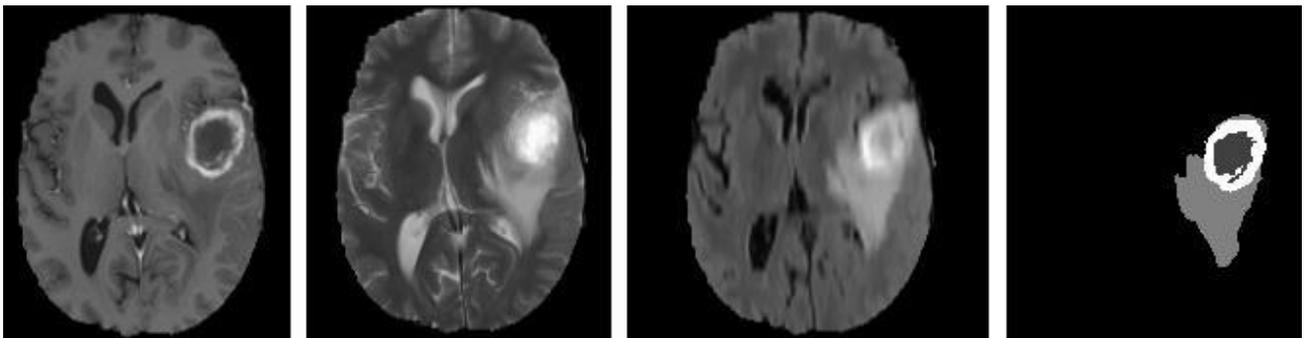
Brain tumor segmentation. From left: T1-Gd, T2, FLAIR and Segmented Tumor. In segmented image; bright signal is active region, dark signal is necrotic core and medium level signal is edema. Images are generated by using BRATS 2013 data<sup>5</sup>.
